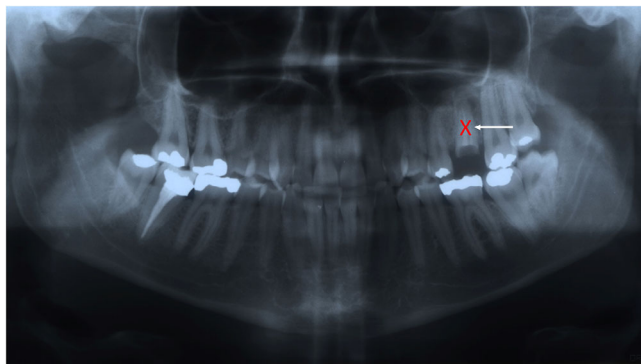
Panoramic radiograph of a 23-year-old patient. The red cross highlights the upper left first molar, scheduled for extraction due to large caries and unrestorable root. The white arrow reminds us of the autotransplantation of the upper left third molar into the socket of the first molar.
